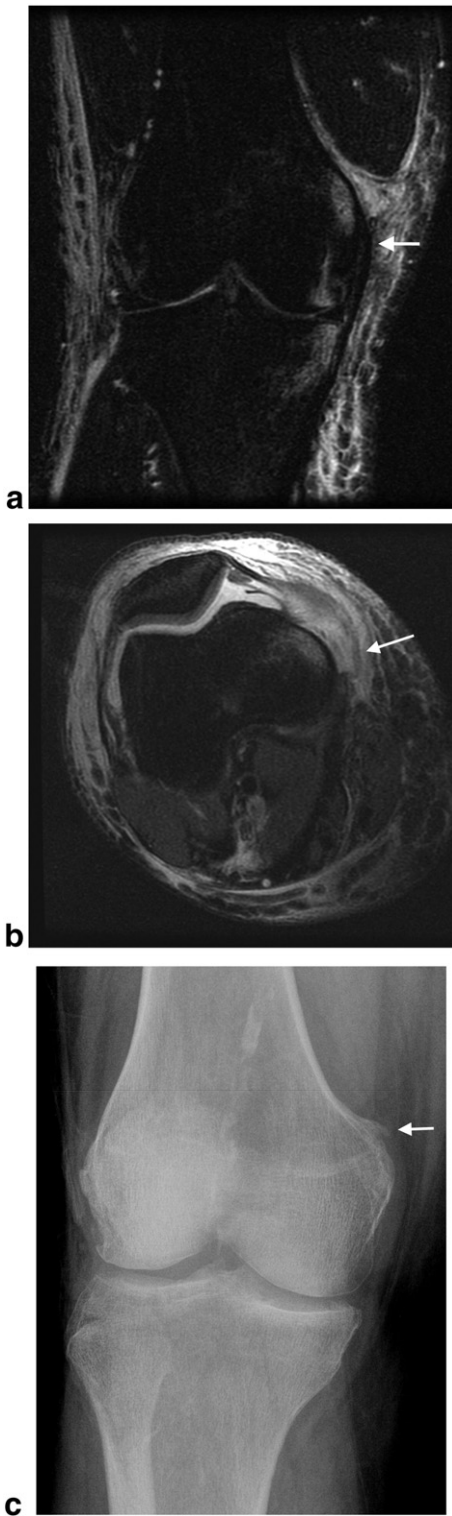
(a) A 65-year-old woman with injury after motor vehicle collision. Coronal PD image of the right knee demonstrates an intact superficial MCL (arrow). (b) Axial PD image through the left knee at the level of the MPFL demonstrates disruption of its posterior attachment (arrow). (c) Follow-up radiograph of the right knee demonstrates interval development of PS-type ossification (arrow), which is “high” in location, relating to the posterior attachment of the MPFL.
